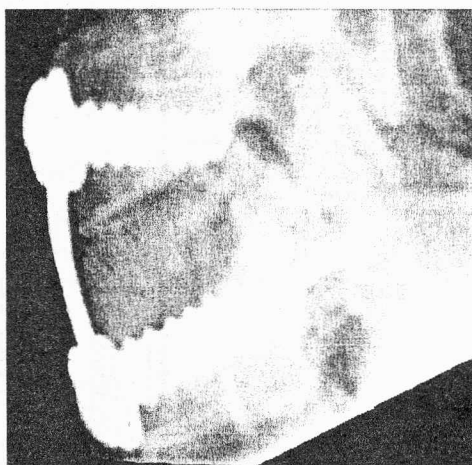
X-ray pictures of two cervical vertebrae with plate fixator and bone graft inserted between vertebral bodies: a) the first few days after insertion of the graft, b) 3 months after insertion of the graft [8]
